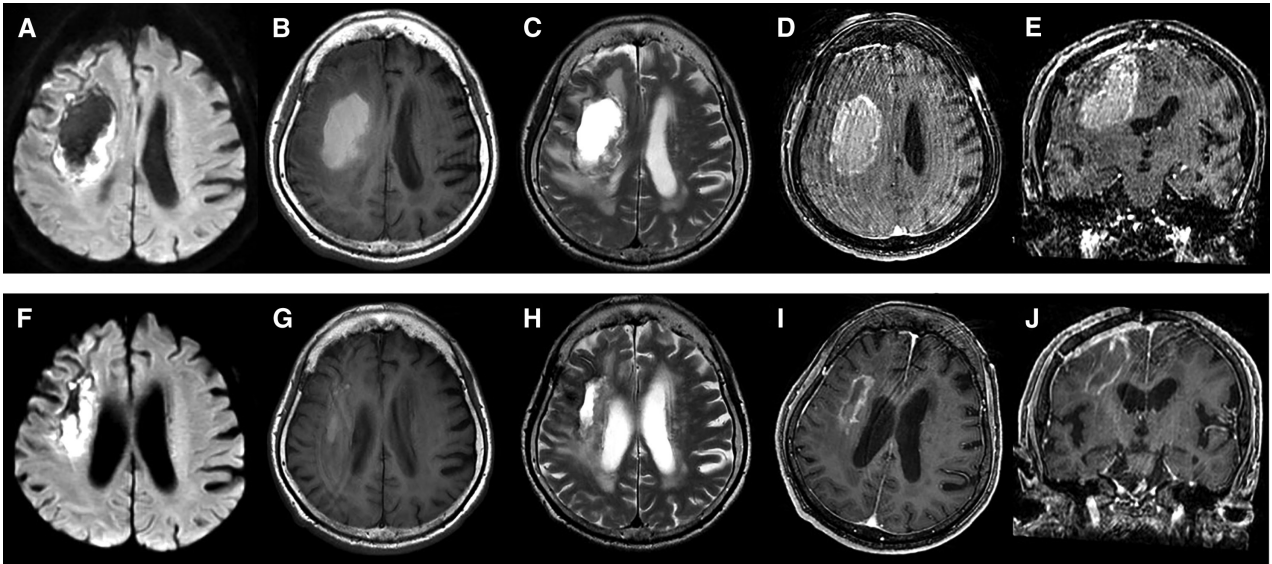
(A–E) Brain MR imaging on postoperative day 16 demonstrating the cyst in the hematoma cavity. Diffusion-weighted image showing hyperintensity on the cyst wall (A). T1-weighted image showing hyperintensity (B). T2-weighted image showing hyperintensity (C). Cyst wall enhancement on axial (D) and coronal (E) MR images after gadolinium administration. (F–J) Brain MR imaging on postoperative day 33 demonstrating cyst shrinkage after steroid treatment. Diffusion-weighted image (F). T1-weighted image (G). T2-weighted image (H). Axial (I) and coronal (J) MR images after gadolinium administration. MR: magnetic resonance.
